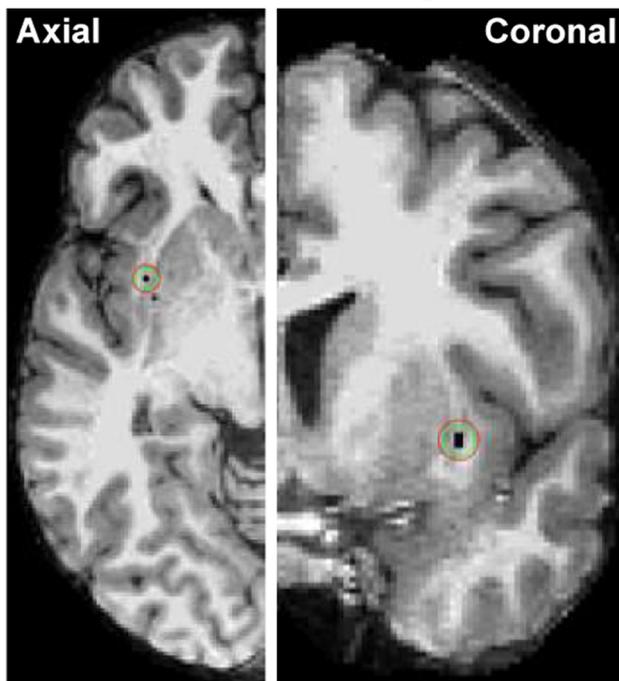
Approximate brain area activated per amount of charge deposited, calculated based on data from [13]. The yellow outline corresponds to the location of claustrum seen in the coronal plane. The pink ellipse shows the size of the depth electrode (LP1 in subject 1, overlaid on the subject's own MRI). The red circle shows the estimated activated area with the highest used stimulation parameters (50 Hz, biphasic, 0.2 ms/phase, 8 mA, for 2 s). The green circle shows the activated area with the most commonly used parameters (50 Hz, biphasic, 0.2 ms/phase, 4 mA, for 1 s). Note the close proximity of the claustrum, the insula (I) and the putamen (P).
